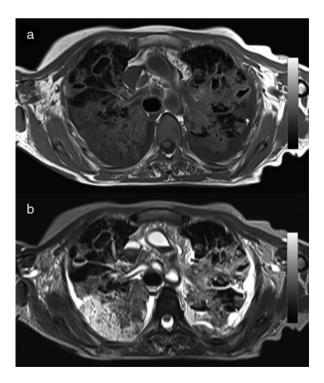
Two different MRI scans showing a case of tuberculosis. (a) T1 weighted scan with bright fat and dark water content. (b) T2 weighted image with bright water content
